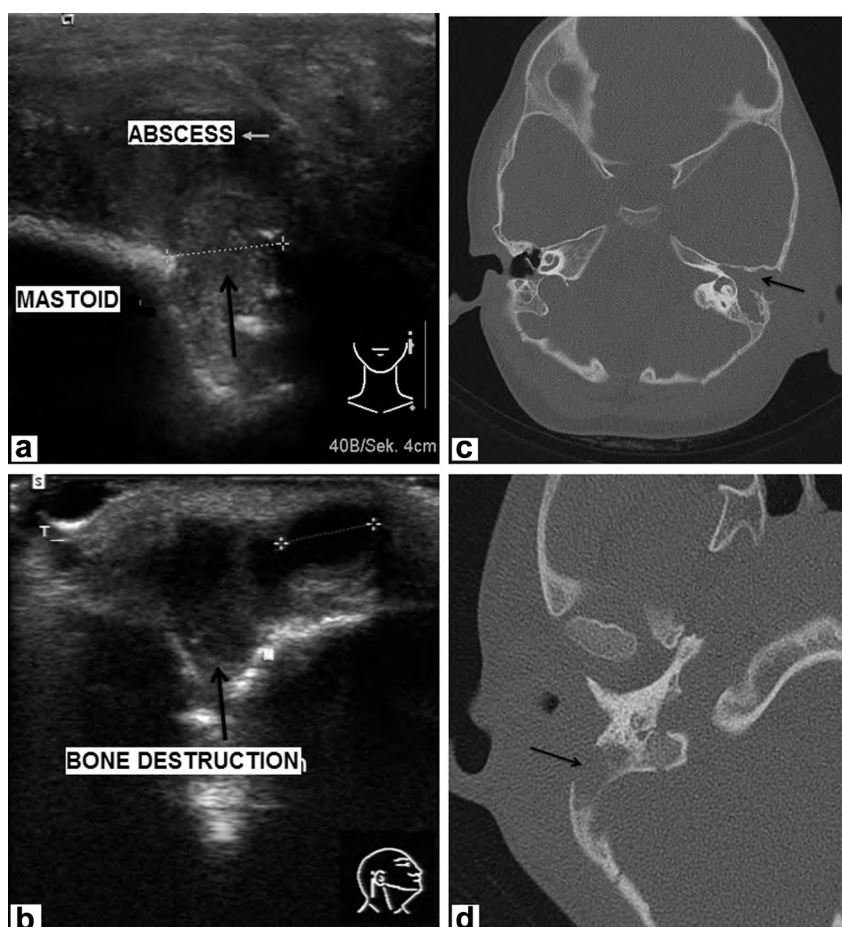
(a, b) Ultrasound findings: Poorly demarcated, inhomogeneous, irregular lesion in the retro-auricular region with disruption of the continuity of the mastoid bone and defect of the external cortex. (c, d) Corresponding computed tomography findings: Delineation of a bony defect of the outer cortex of the temporal bone (*arrows*).
